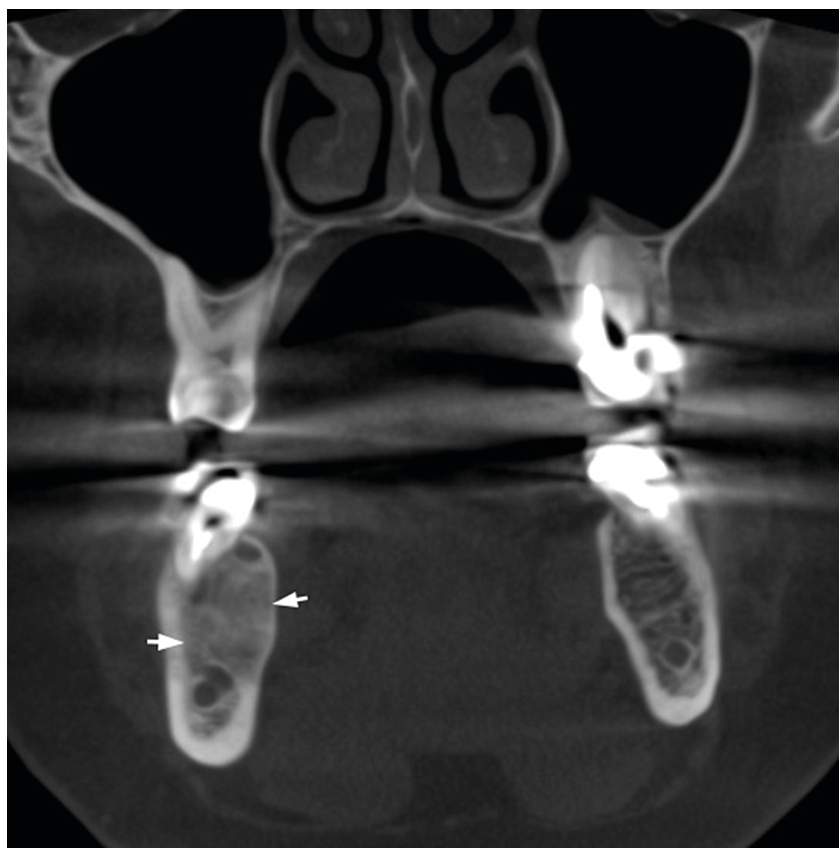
CBCT coronal scan 5 months after biopsy (minimally invasive perforation the buccal cortical bone and curettage with stimulation of blood clot formation) at the level of tooth #46 (projection of anterior camera of SBC). Noted a complete fulfillment only the anterior cystic camera (in which biopsy was performed) with a bone (range from 16 HU to 362 HU) that is denser than on the contralateral site (range from -235 HU to 204 HU).
